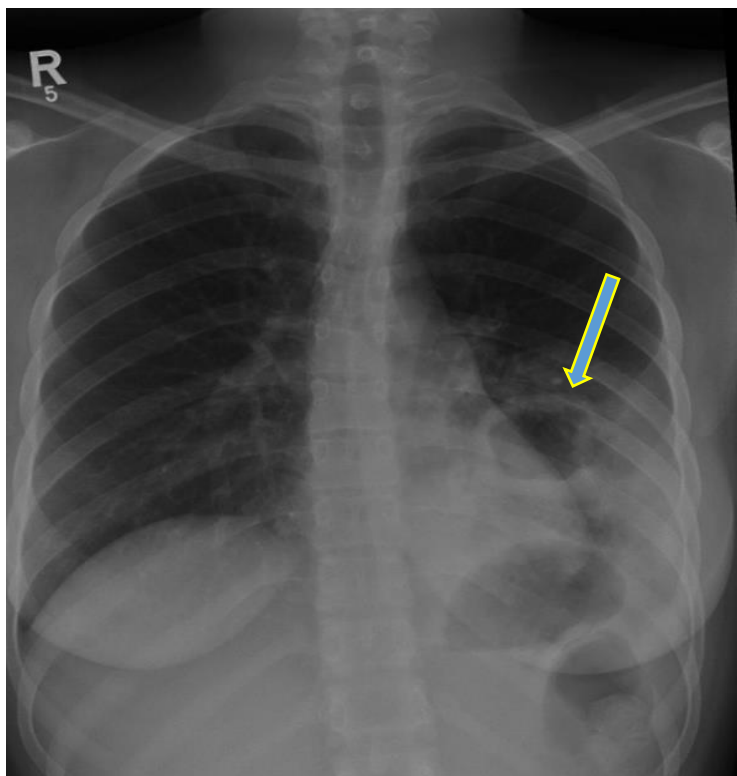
Chest x-ray of patient with pulmonary tuberculosis
